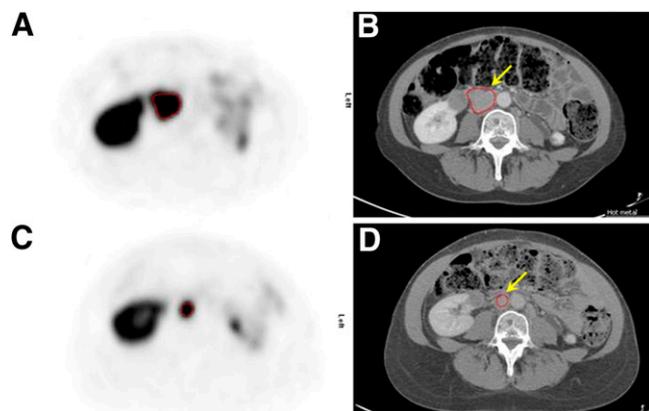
Pretherapeutic axial PET (A) and CT (B) slices, compared with posttherapeutic PET (C) and CT (D) slices, showing abdominal lymph node metastasis (arrow) of patient 6. Both SUV_{max} (-55%) and $SUV_{T/S}$ (-60%) decreased markedly after PRRT. This patient has been progression-free for 28 mo.
